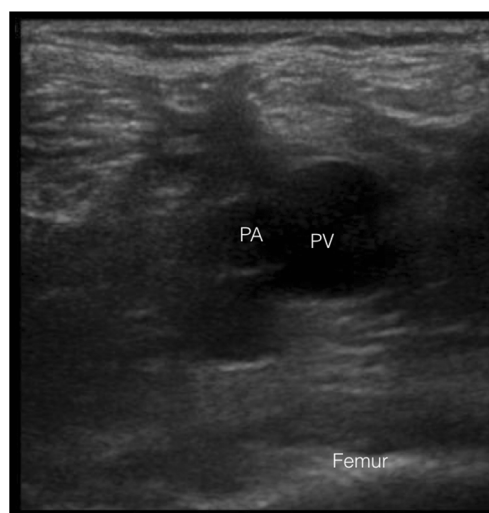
Ultrasound image of the IPACK block. Local anesthetic should be deposited in the space between the popliteal vessels (PA: Popliteal artery, PV: Popliteal vein) and the distal femur
